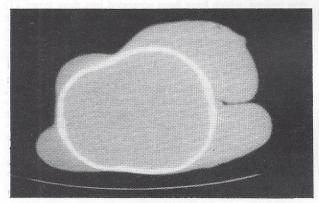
CT scan of the head. Huge extracranial soft tissue tumours over occipito-parietal areas. No haemorrhage, necrosis, bone erosion or intracranial abnormalities
